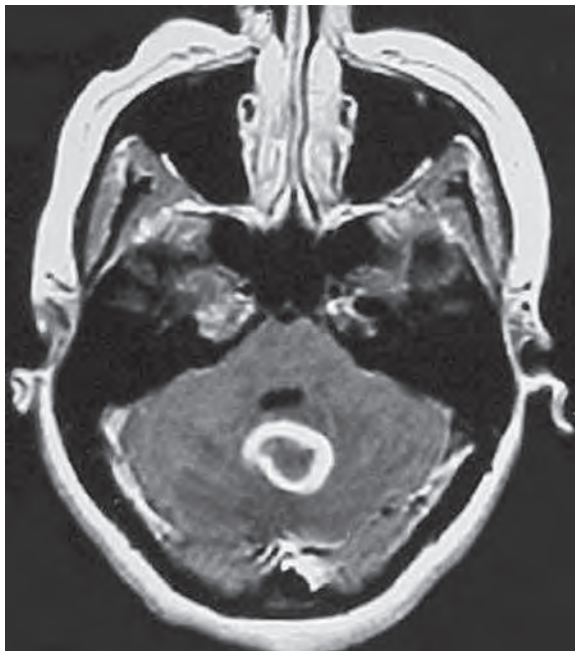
T1-weighted axial MRI scan of a patient with vermian tuberculoma
